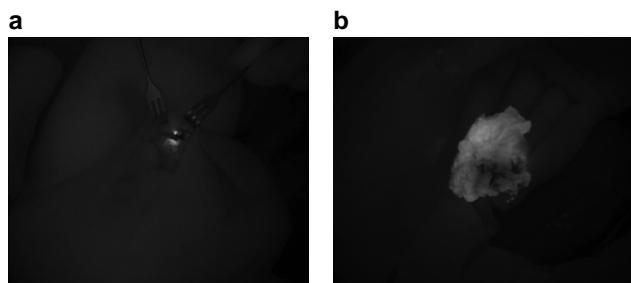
Intraoperative images of indocyanine green-guided tumour localization after ultrasound-guided intratumoral indocyanine green injection
